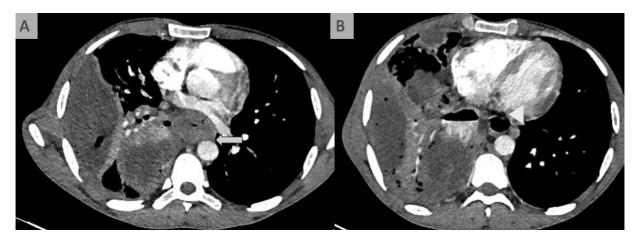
Esophagopleural fistula in esophageal cancer. (A and B) Axial contrast-enhanced computed tomography (CT) scan shows asymmetric circumferential mural thickening involving the mid thoracic esophagus (arrows). An irregular, thick-walled collection with air fluid level showing contrast extravasation in the right pleural cavity. Multiple air foci are seen within. There is passive collapse of the underlying lung segments (arrowhead).
